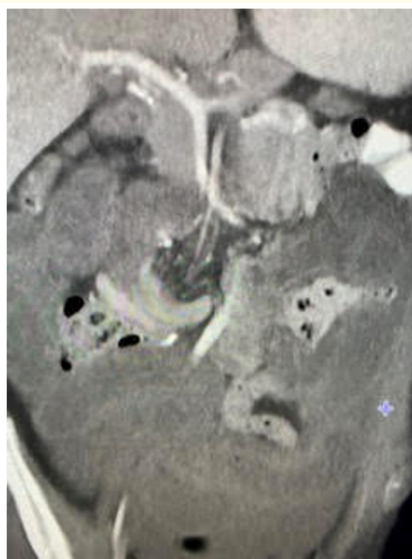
CT showing ischemic bowel on POD #10.
